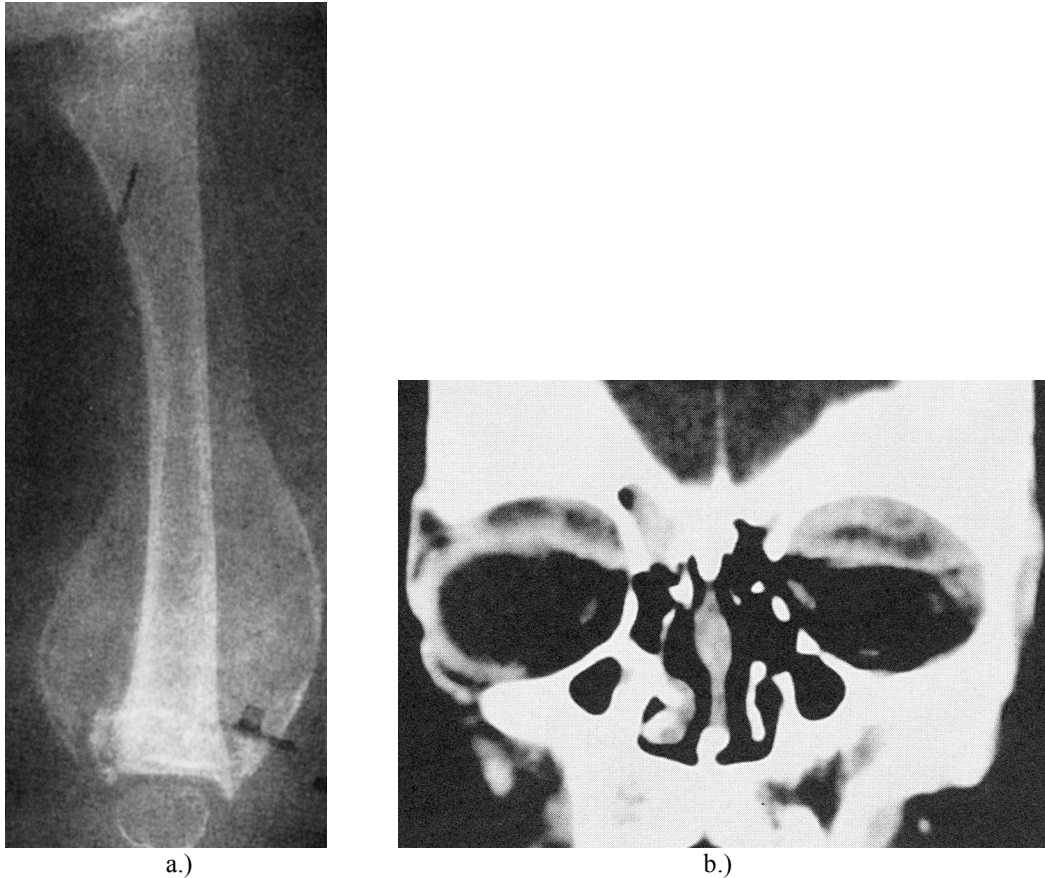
a.) Radiographic example of a healing subperiosteal hemorrhage can be clearly seen along the distal extent of the tibia (Burgener 2006b: fig. 3.10), b.) Bilateral subperiosteal hemorrhaging and hematomas along the orbital roofs can be clearly observed from this coronal CT scan of a child with scurvy (Brickley and Ives 2008: figure 4.5).
